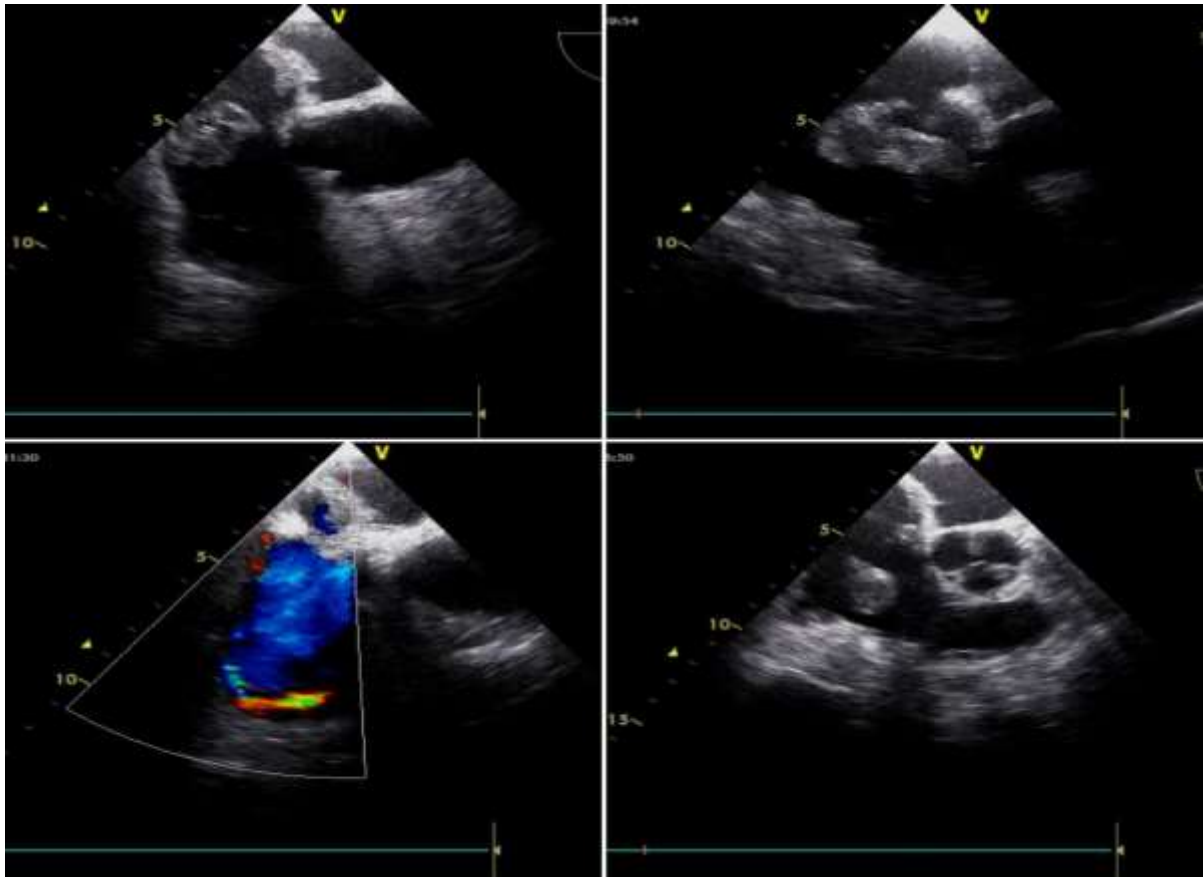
Trans-esophageal echocardiography (TEE) showed a massive in-transient emboli of RA, RV, and RVOT
